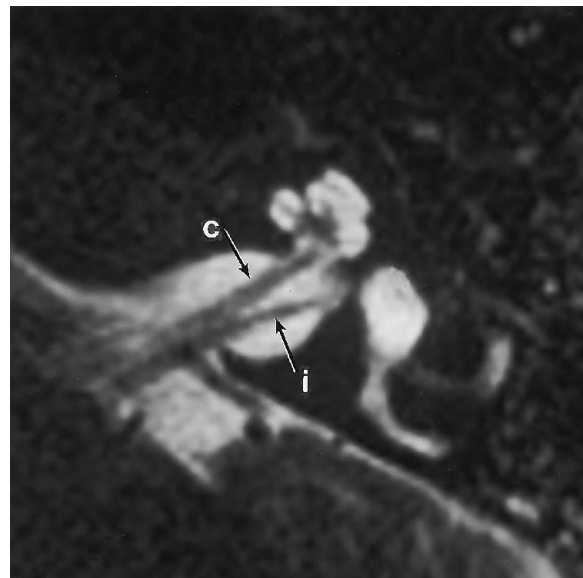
Axial thin-section T2-weighted fast spin-echo magnetic resonance image through the inferior aspect of the internal auditory canal demonstrates the cochlear nerve (*c*) anteriorly and the inferior vestibular nerve (*i*) posteriorly (arrows).
